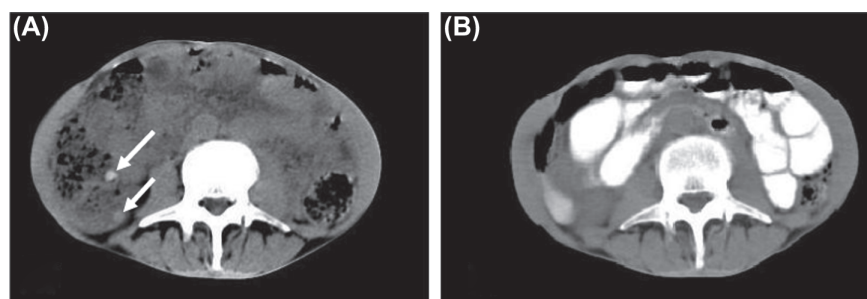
(A) Abdominal CT image of a body stuffer without oral contrast shows two small packets (white arrows) in the ascending colon which is then obscured by the ingested oral contrast in next CT image (B).
